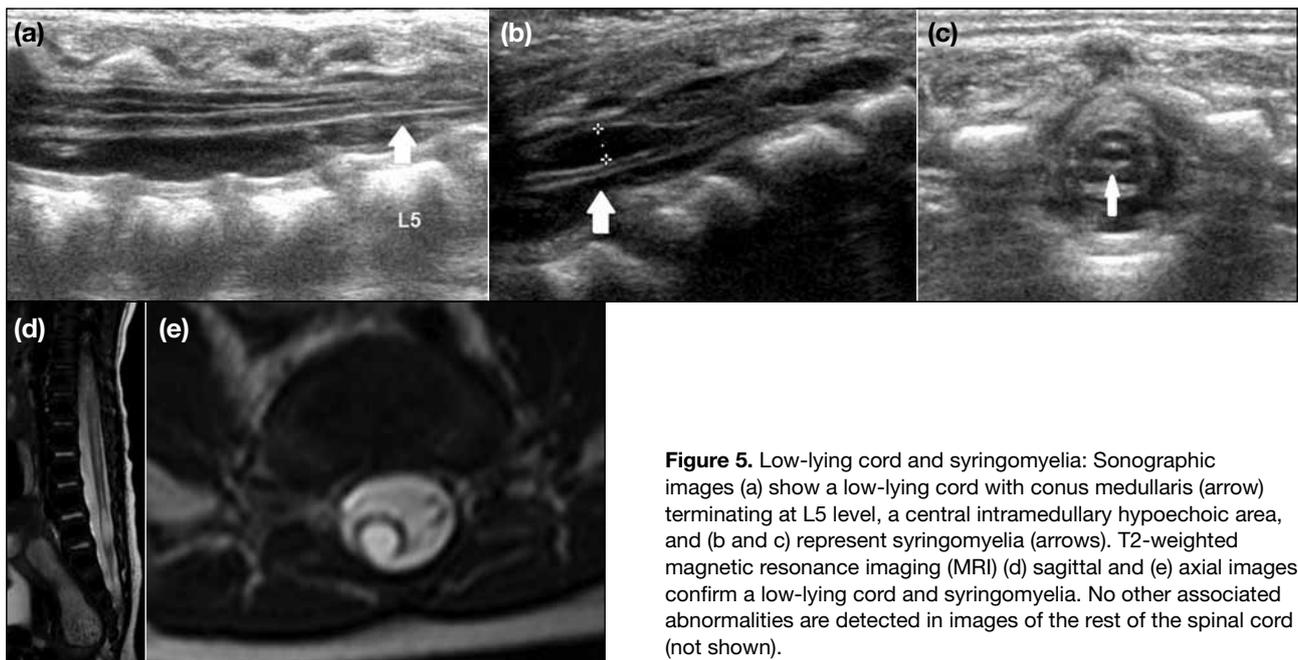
Low-lying cord and syringomyelia: Sonographic images (a) show a low-lying cord with conus medullaris (arrow) terminating at L5 level, a central intramedullary hypoechoic area, and (b and c) represent syringomyelia (arrows). T2-weighted magnetic resonance imaging (MRI) (d) sagittal and (e) axial images confirm a low-lying cord and syringomyelia. No other associated abnormalities are detected in images of the rest of the spinal cord (not shown).
